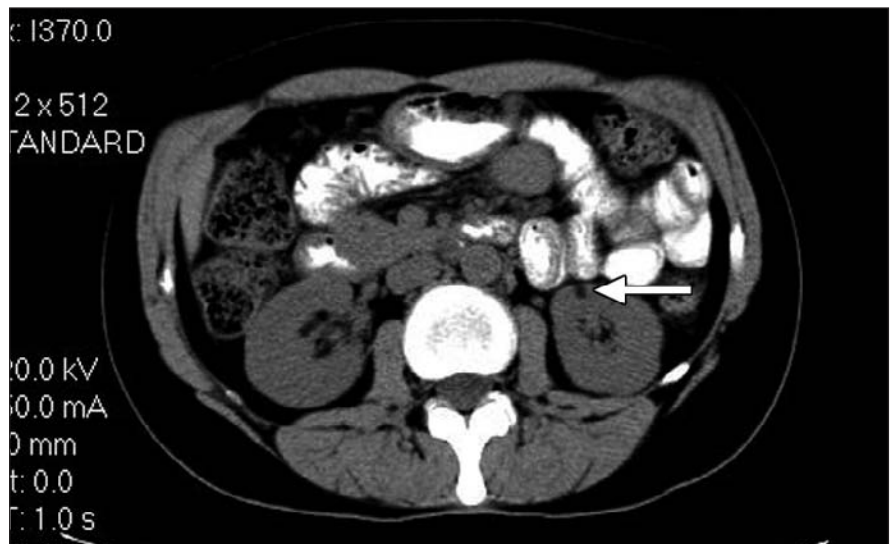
CT scan of the abdomen showing renal angioliipoma (arrow).
